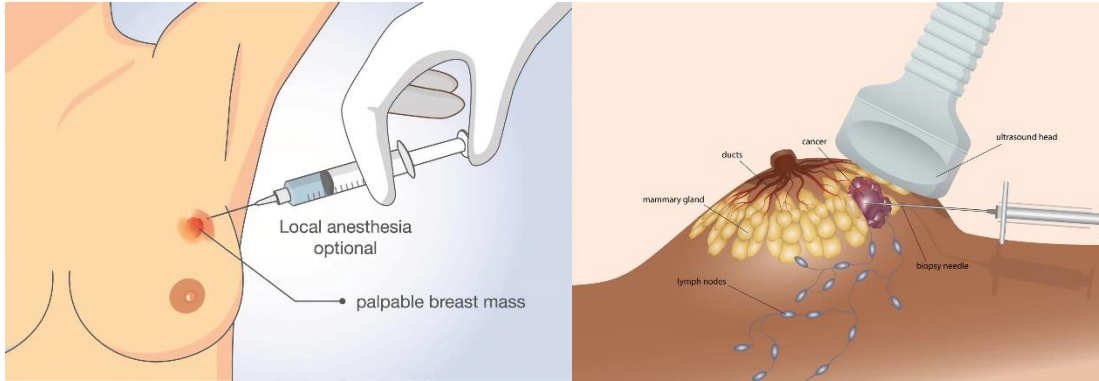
Fine needle aspiration biopsy(left) vs core needle biopsy with ultrasound(right)
